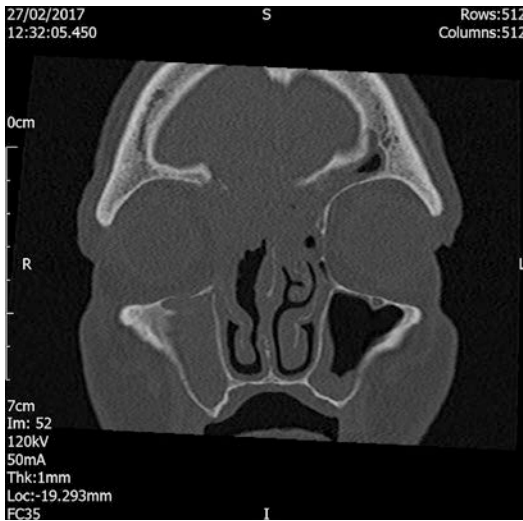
Coronal CT of the paranasal sinuses demonstrating a destructive sino-nasal lesion with involvement of the skull base and right orbit
